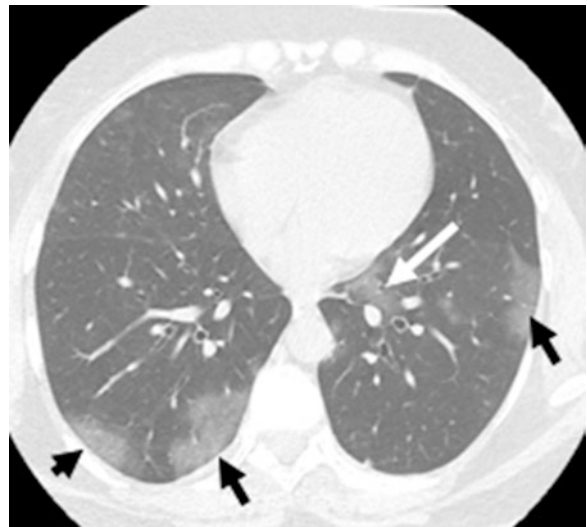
Axial chest CT with lung window. Multiple ground-glass pulmonary opacities in a COVID-19 patient. Lesions are mostly subpleural (black arrows) but with a single central lesion (white arrow)
